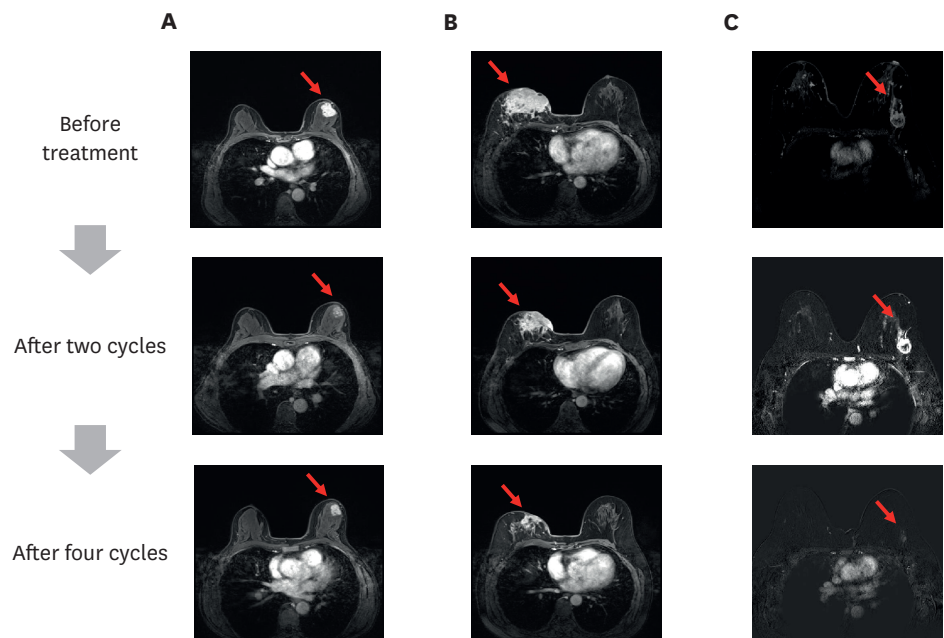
MRI images from cases of the three radiologic response rate patterns. The red arrows indicate the cancer lesion.
